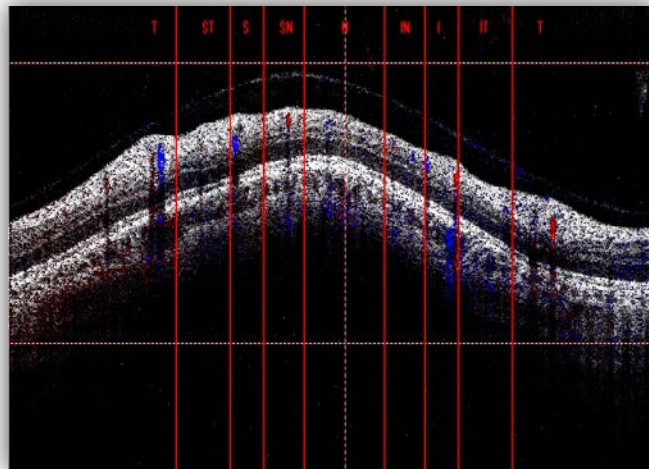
Doppler OCT image for OCT beam passing through the superior nasal quadrant of the pupil. The peak of the sinusoidal could be positioned within either superior or inferior quadrant of the pupil i.e. within the respective solid vertical red line as shown in this picture.
